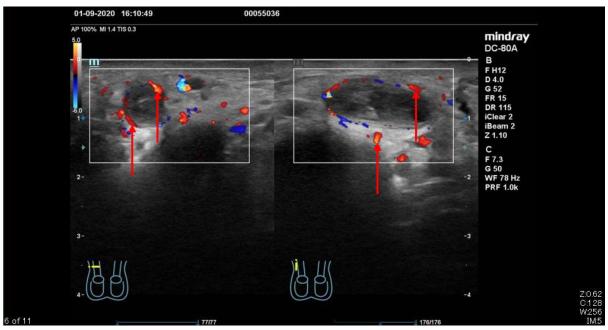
The right spermatic vein lumen with no Doppler color was seen. Doppler flow was normal within the neighboring arterial structures (red arrows).
